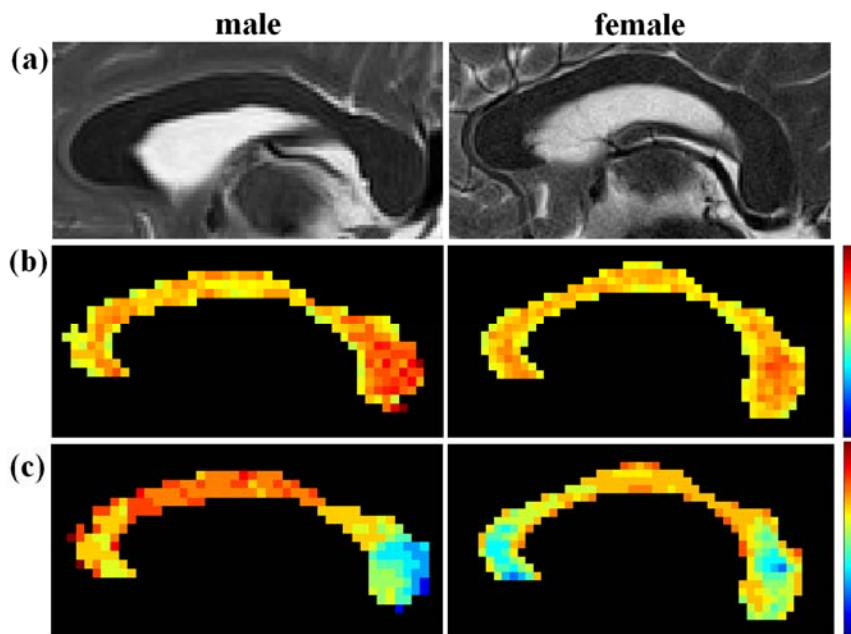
QPI analysis of the human CC. Sagittal indexed MRI maps of (a) T2WI, (b) probability and (c) displacement of narrow Gaussian displacement distribution in representative male (left column) and female (right column) normal subjects.
